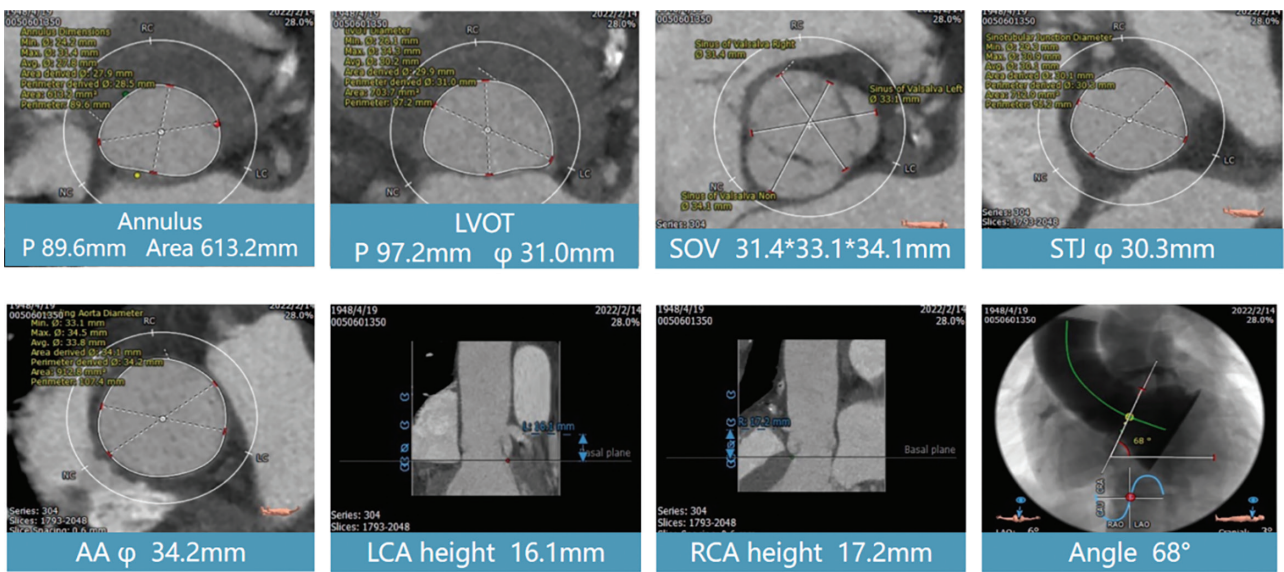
Preoperative CT Evaluation, Showing the Dilated Annulus (Area 613.2 mm², Perimeter 89.6 mm) and Normal Ascending Aorta Dimensions.
